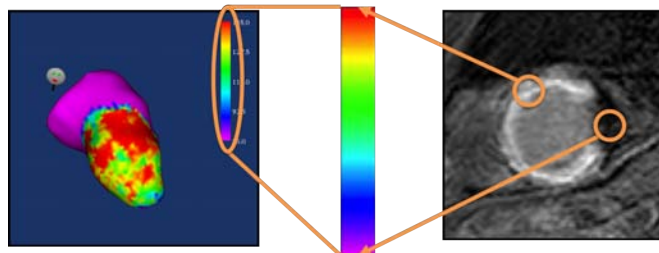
Colormap range selection based on healthy and deep-scar regions from the DE-MRI data.
